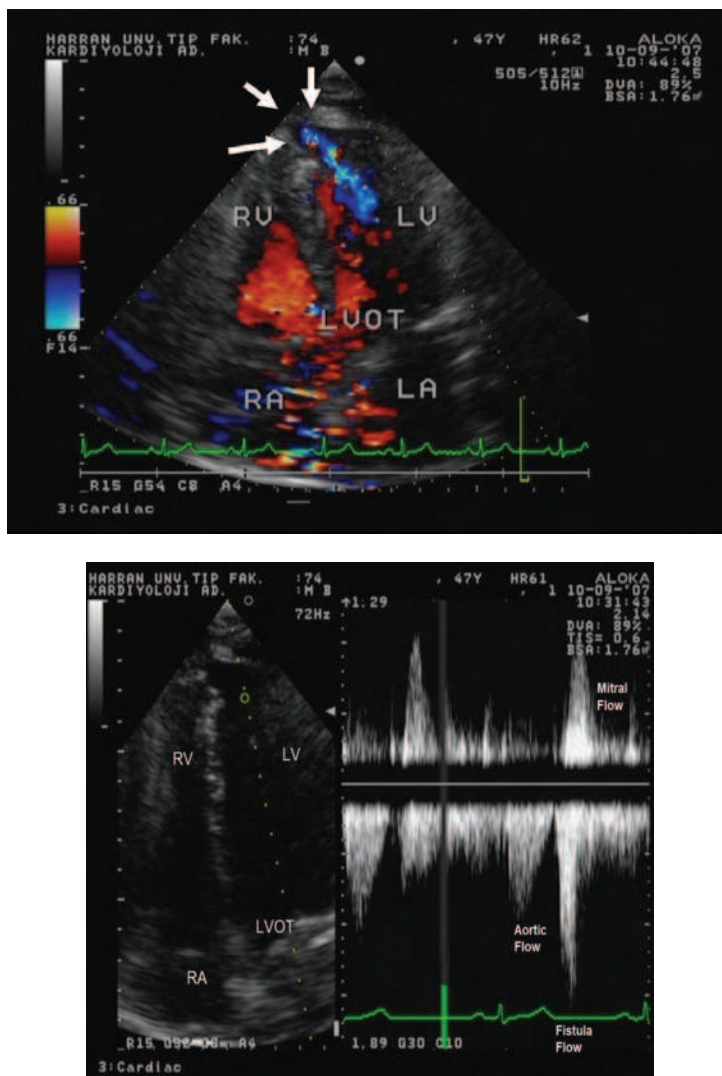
Colour Doppler and continuo Doppler show fistula form coronary artery to left ventricle. Colour Doppler and continuo Doppler at apical four-chamber view from a transthoracic echocardiogram shows drainage of fistula into the left ventricle apex in diastolic period. IVS; inter-ventricular septum, LV; Left ventricle, LVOT; left ventricular outflow tract, RV; Right ventricle, RA; Right atrium.
